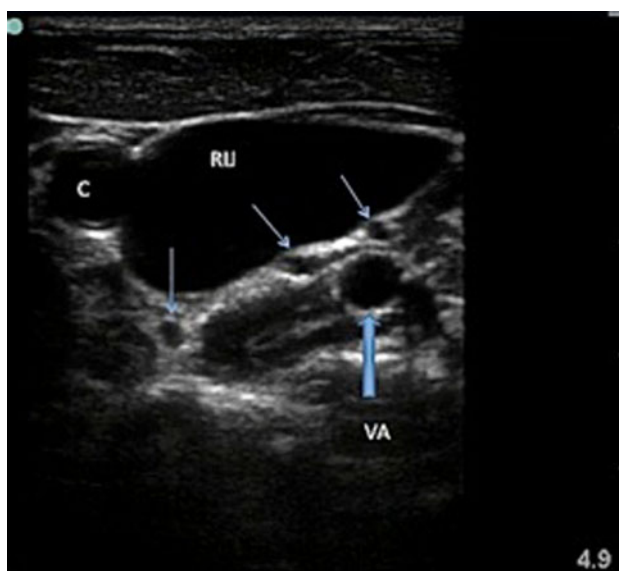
Cross-sectional image through vessels as the base of the right neck as viewed from above the patient's head. The carotid artery (C) and large right internal jugular (RIJ) vein lie side by side. High-resolution ultrasound and accurate needle visualisation allow such collateral structures to be identified and avoided. The artery behind the vein vertebral artery (VA) is the thyro cervical trunk (a major branch of the subclavian artery), which is clearly vulnerable if the vein is transfixed out of plane by a needle in this area
